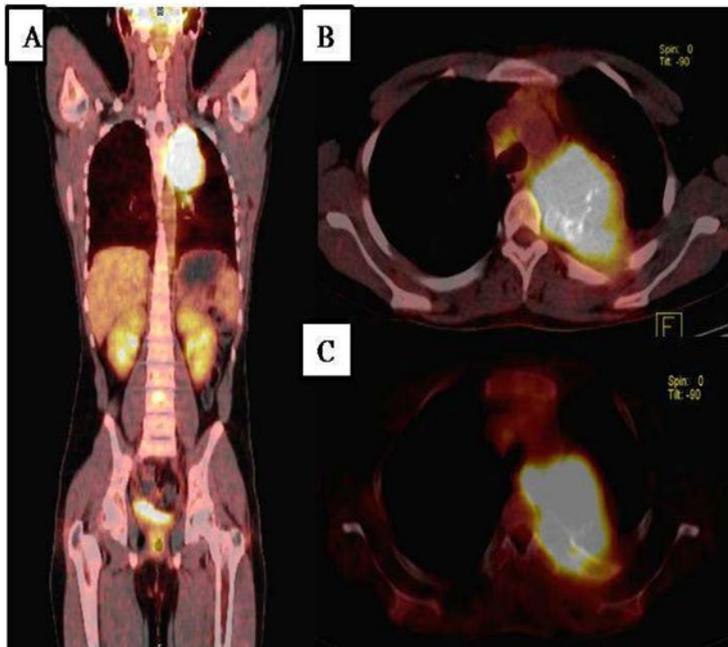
year-old male with history of Ewing sarcoma (A) Coronal 1st PET/CT for staging showed left paravertebral lesion arising from left 3rd & 4th ribs with soft tissue component , mediastinal nodal & skeletal (LV-4) metastases.
